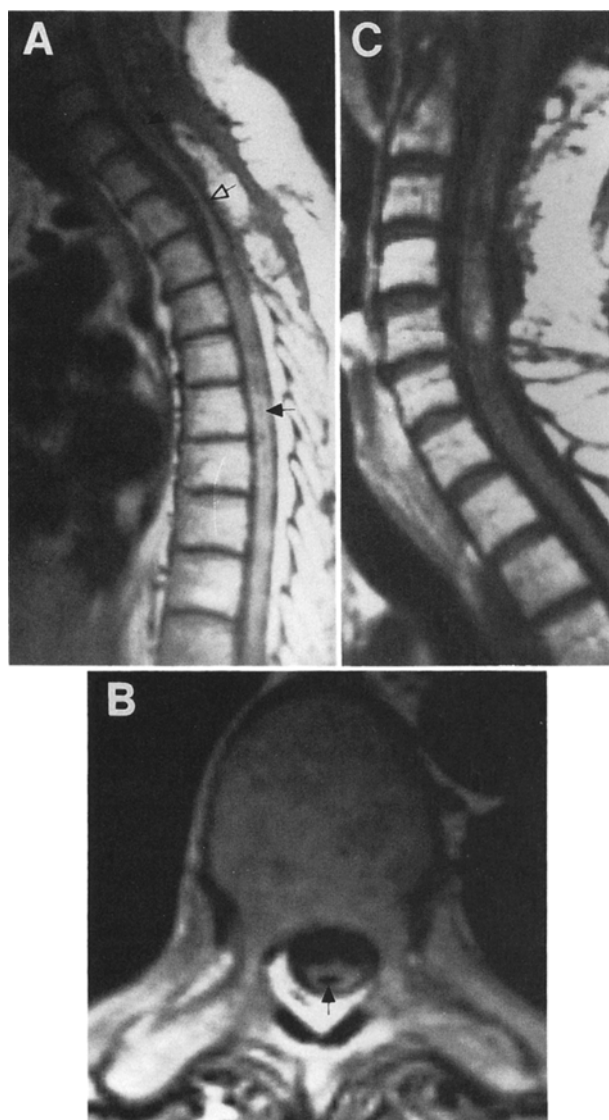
A: Postoperative T₁-weighted sagittal magnetic resonance (MR) image showing spinal cord atrophy, most marked at the level of tumor resection (*open arrow*). There is dorsal tethering of the spinal cord and a large ventral subarachnoid space at this level. Persistence of both rostral and caudal cysts can be seen (*closed arrows*). B: T₁-weighted axial MR image performed three spinal segments below the level of tumor resection in the same patient better demonstrates the persistent intramedullary cyst (*arrow*). C: Postoperative T₁-weighted gadolinium-enhanced MR image in another patient demonstrating an area of increased signal intensity at the level of previous tumor resection. This area has not changed on serial MR images performed over a 3-year period.
